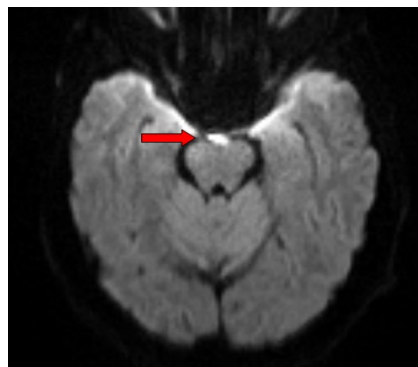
Brain MRI, diffusion-weighted sequence (slice thickness: 5 mm): hyperintense signal in the midline perimesencephalic region consistent with a perimesencephalic subarachnoid hemorrhage (red arrow).
